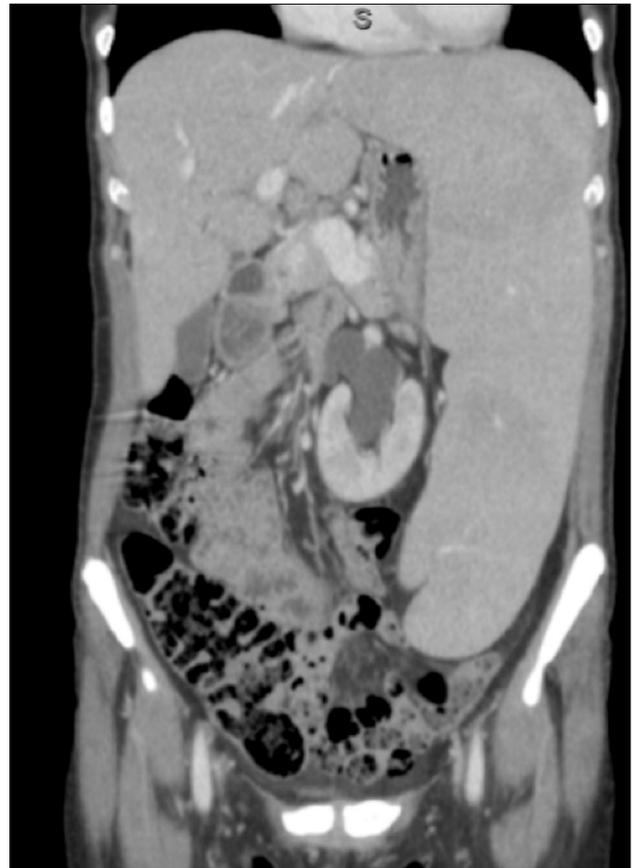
Computed tomography (CT) scan demonstrating subtle hepatomegaly and greatly increased spleen size.
